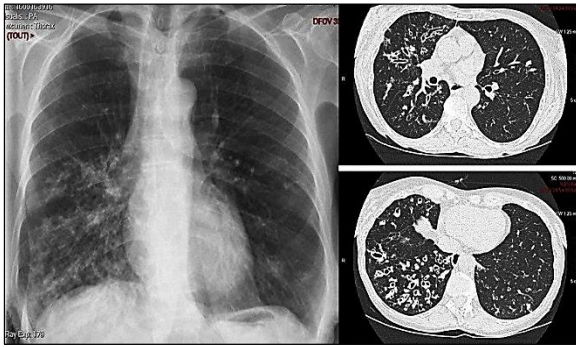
Chest Radiograph and CT images of Bronchiectasis
